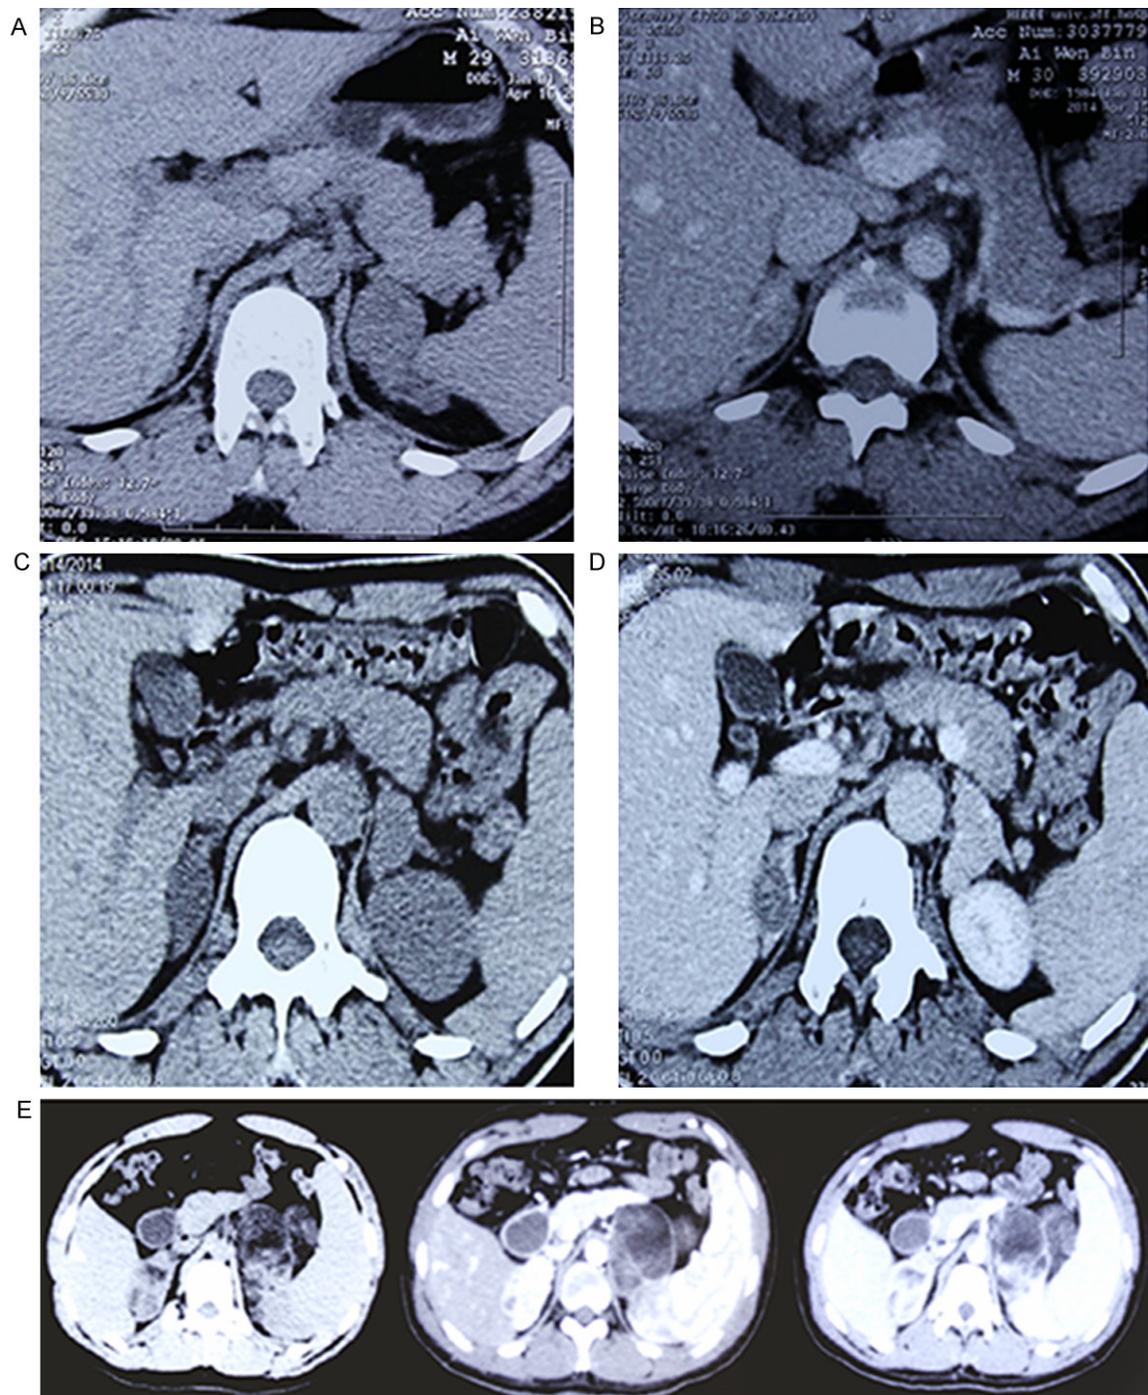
Computed tomography images of the adrenal glands of Case 1. A. Preoperative CT showing bilateral adrenal masses (left: 3.6×3.1 cm; right: 2.1×0.8 cm). B. Adrenal CT at 1 year postoperative follow-up showing enlargement of the left adrenal and a mass of the right adrenal (2.4×1.6 cm). C and D. Computed tomography images of the adrenal glands of Case 3. Bilateral adrenal masses are seen. E. Computed tomography images of the adrenal glands of Case 4. Bilateral adrenal masses are seen.
